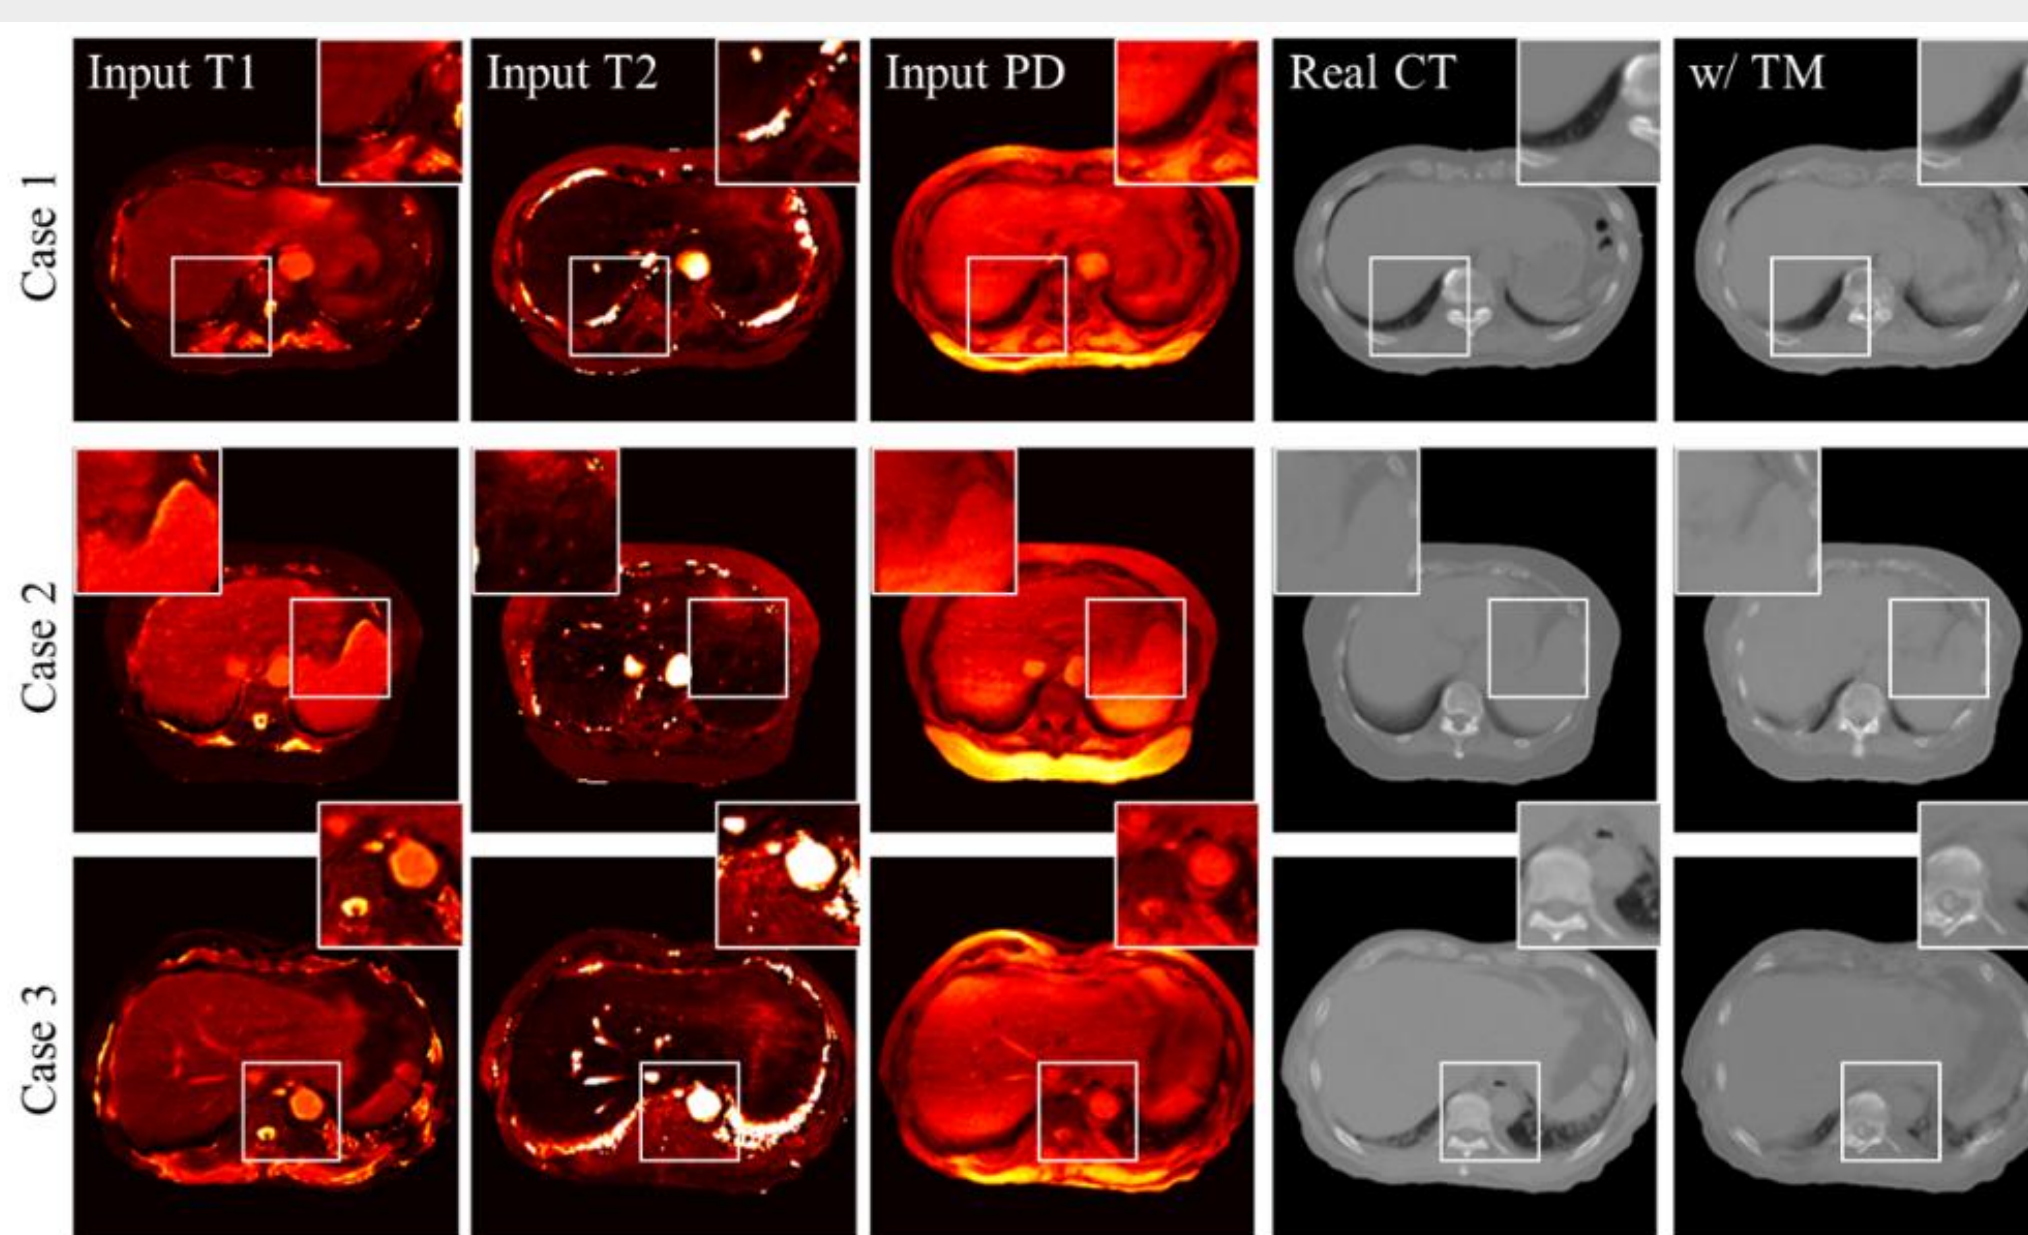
Representative synthetic CT generated by the DRFT model compared to the ground-truth planning CT and the input MRF parameter maps.
